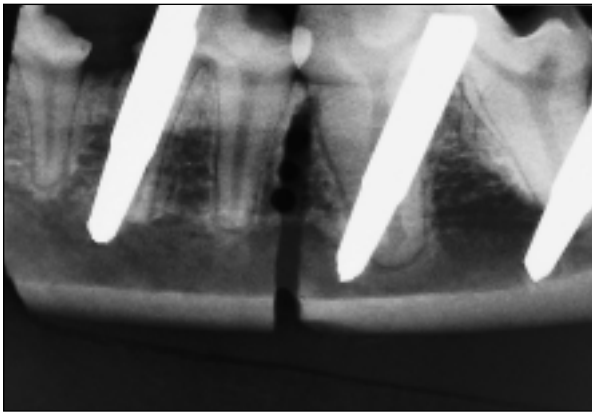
Radiograph taken immediately after the corticotomy.
